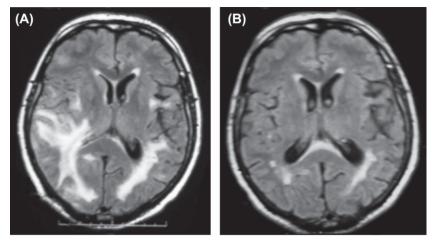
(A) Axial magnetic resonance imaging (MRI) obtained at admission shows bilateral predominantly parieto-occipital subcortical hyperintensities. (B) Follow-up MRI performed 15 days later showing marked reduction of MRI abnormalities.
